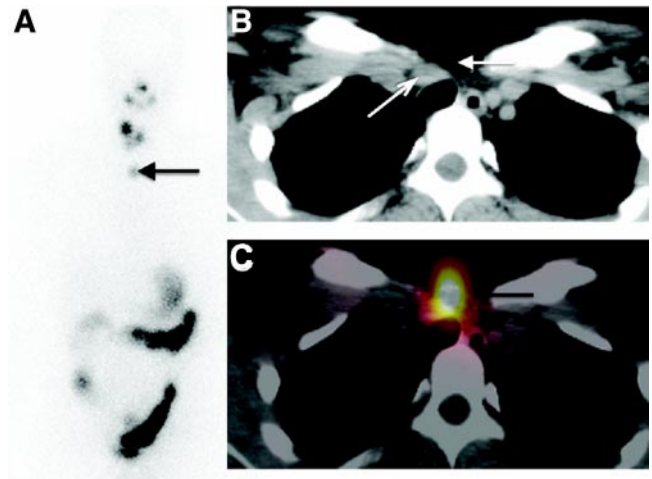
Postablation ¹³¹I WBS and SPECT-CT in patient 41 described in Table 3. A, Intense focus of iodine uptake localized in the mediastinum and scored as indeterminate on the anterior view of planar WBS. SPECT-CT enabled identification of this focus as normal thyroid remnant located at the cervicomedastinal junction, in front of the brachiocephalic vein (B and C, CT and fused SPECT-CT transaxial slices). This patient remained disease free after a follow-up of 23 months.
